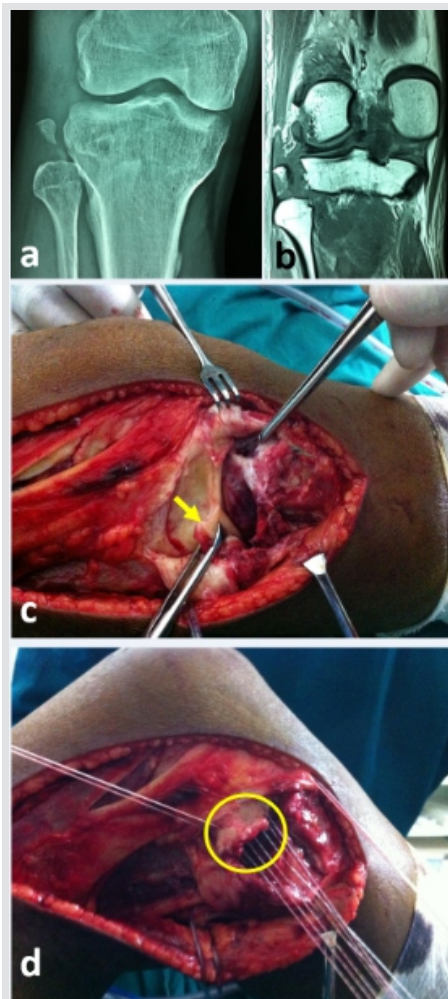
Repair of posterolateral corner structures. (a) Plain anteroposterior radiograph showing an avulsion of fibula head which contains attachments of the fibular collateral ligament (FCL) and biceps tendon. (b) MRI scan T2-weighted coronal image showing the osseous fragment with attached FCL. (c) Lateral exposure showing the avulsed FCL (yellow arrow). (d) En-masse trans-osseous repair (yellow circle) of all bone and ligaments was performed.
